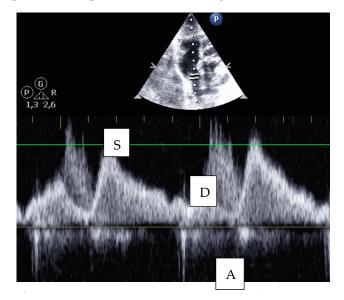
Subcostal view: PW Doppler signal from the superior vena cava with systolic (S), diastolic (D), and atrial (A) waves.
